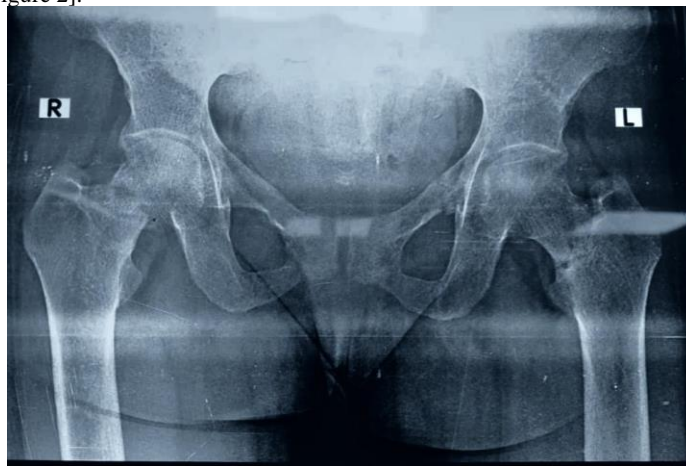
X-Ray- AP pelvis radiograph showing bilateral femoral neck fracture
